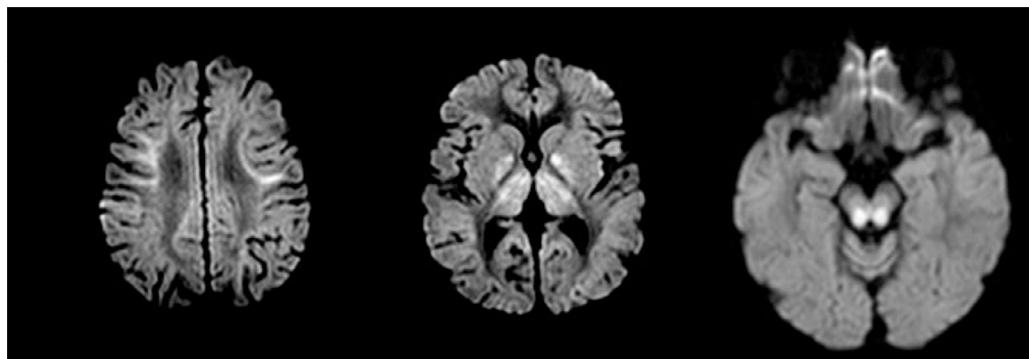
Diffusion-weighted sequence (DWI b: 200) showing diffusion restriction in the affected areas.
